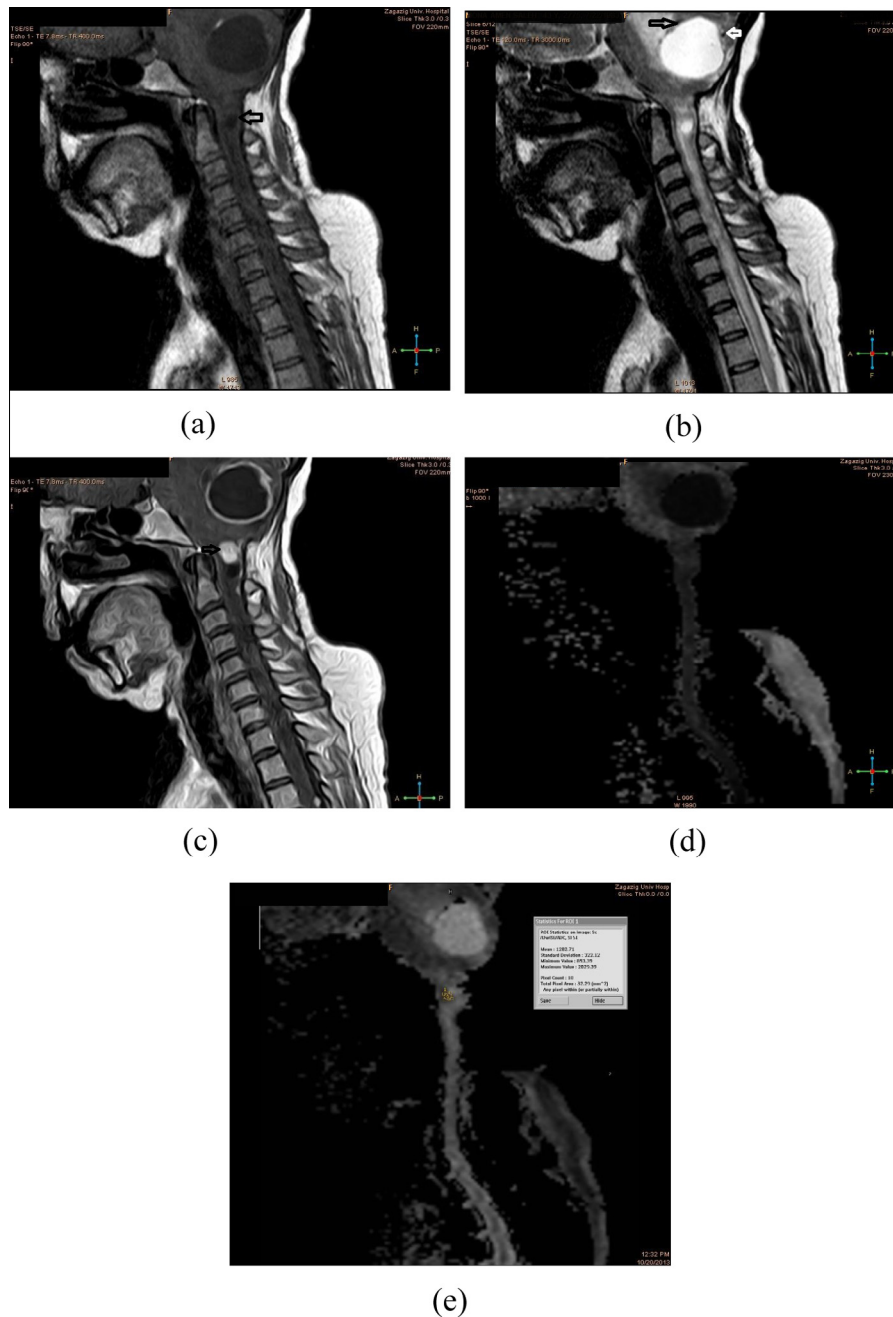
43-years-old female patient presented with three year history of severe headache, dizziness, unsteadiness, and tingling in upper limbs. Sagittal T1-WI (A), sagittal T2 WI (B) and sagittal T1WI post contrast (C) image show a large, well-demarcated cystic cerebellar and upper cervical intramedullary (arrow) cord lesions tumor opposite C 2 level. Homogenous hypo-intense solid nodule inside each cyst is noted and these nodules show intense and homogeneous enhancement (arrow in C). Vascular flow voids in and around the tumor (arrows), proved to be dilated veins at surgery. Hydrocephalic changes by the cerebellar mass and syringomyelia noted in the cervical cord. DWI (D) and ADC (E) are showing no restricted diffusion of the lesions, solid and contrast-enhancing portions appeared low signal on DWI. The ADC was increased ($1.2 \times 10^{-3} \text{ mm}^2/\text{sec}$). The findings of conventional MRI with DWI data, the case was diagnosed as low grade hemangioblastomas (Von Hippel-Lindau syndrome).
